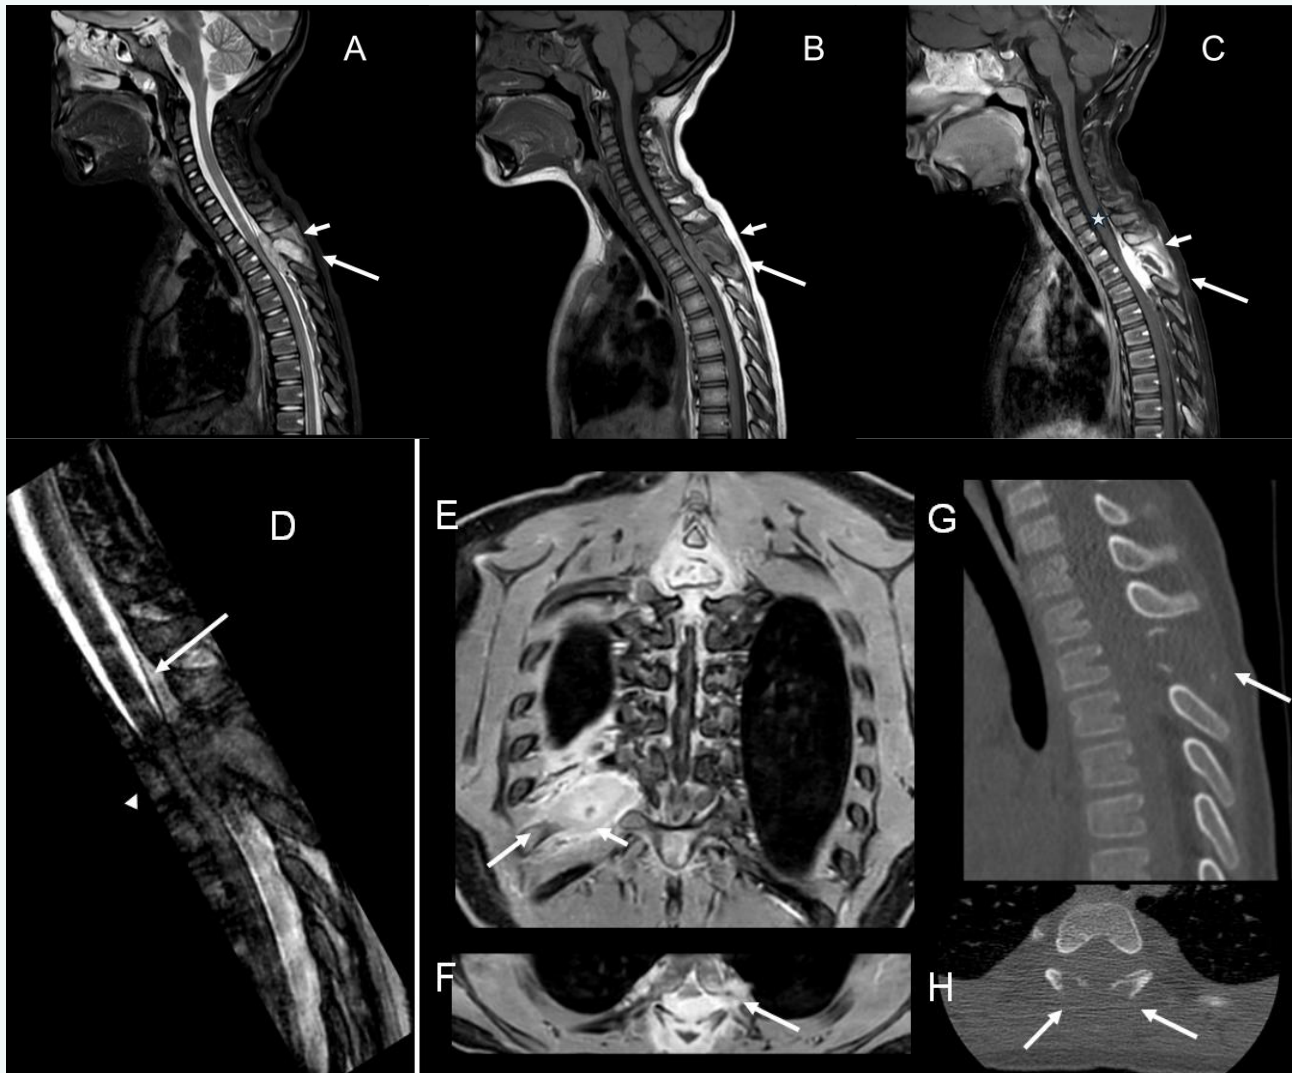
A show a sagittal T2 TSE image and B a sagittal T1 TSE demonstrating dishomogeneous T2 hyperintensity of the lesion and T1 hypointensity with conspicuous contrast enhancement (C; T1 Fat Sat). Involvement of interspinous soft tissue (arrow head) and spinous process (arrow) of D3 is noted, with a central component characterized by lack of contrast enhancement, representing possible necrotic tissue. Subtle dural thickening is noted (star). No frank associated myelopathy is noted. D show a sagittal reformat of an heavily T2 weighted high resolution images show the presence of an intracanalicular roughly ovoid expansile lesion with an extradural epicenter, demonstrated by the dural dislocation (arrow). The lesion extend from C7 to D5. Cord compression is noted (arrowhead). In E a coronal T1 Fat Sat image with contrast demonstrate a second lesions involving the VIII right rib (arrow) with a necrotic center (arrowhead). F show the canal involvement of the lesion with extension to the foramina (arrow) on a post contrast T1 Fat sat image. CT imaging demonstrate erosion of the spinous process (arrow in G) and of the lamina (arrows in H) of the vertebral body of D3.
